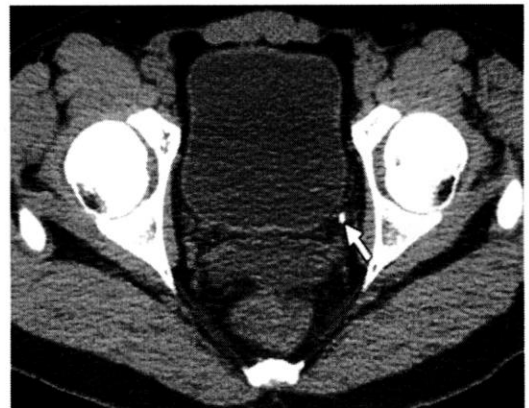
Ureteric stone in a patient who presented with acute left flank pain. Axial unenhanced CT scan shows a 4mm stone in the left distal ureter (arrow) (11).
